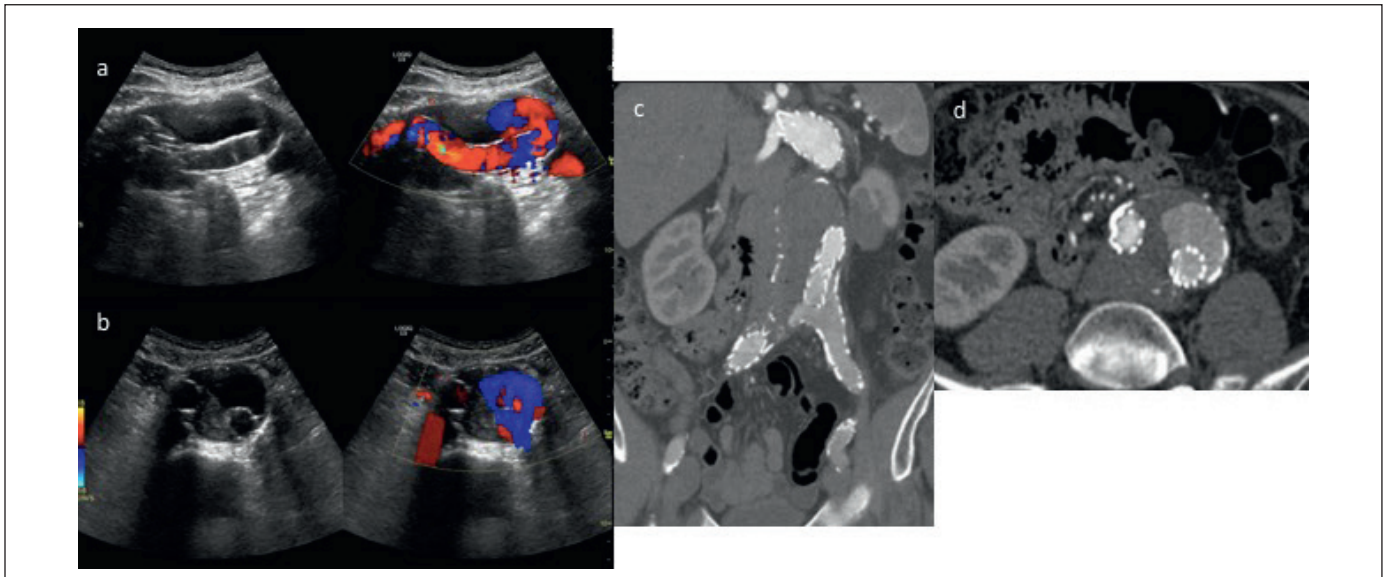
Type 1 B Endoleak. Sagittal (a) and axial (b) greyscale and Doppler images demonstrate Doppler flow outside of the graft toward the left side in the distal aorta. Coronal (c) and axial (d) CTA images demonstrate proximal migration of the left limb of the graft with endoleak filling from below into the aneurysm sac.
